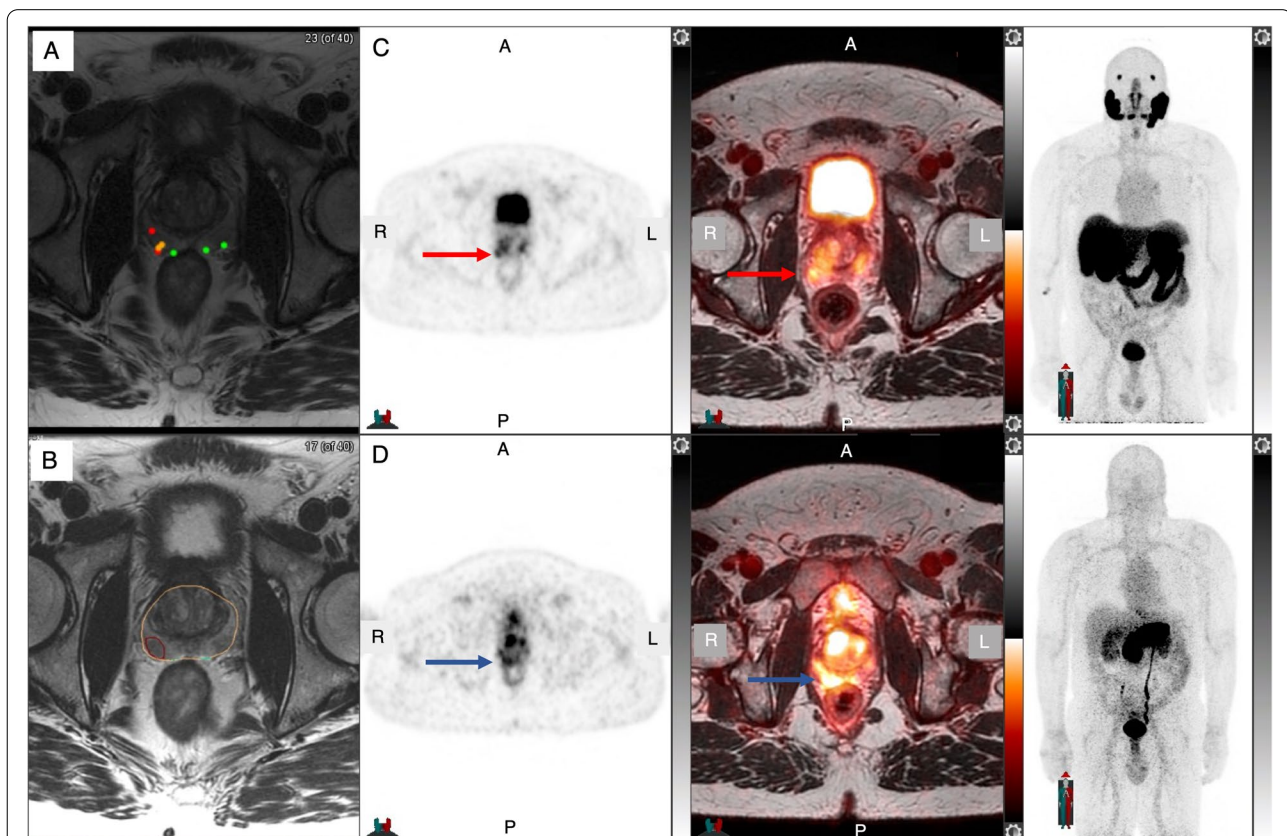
62-year-old man with PSA 7.0 ng/mL and PSA density 0.24 ng/mL². MRI shows a PI-RADS 4 lesion in the right lateral base with color coded needle tracks from biopsy; green-benign, yellow-Gleason score 3 + 3, red-Gleason score 3 + 4 or higher A, and target tumor volume B. ^{68}Ga -PSMA11 C and ^{68}Ga -RM2 D axial PET, axial fused PET/MRI, and MIP show congruent focal uptake in the right prostate lesion. The lesion was treated with HIFU; resolution on both ^{68}Ga -PSMA11 and ^{68}Ga -RM2 PET/MRI was seen 6 months after treatment
